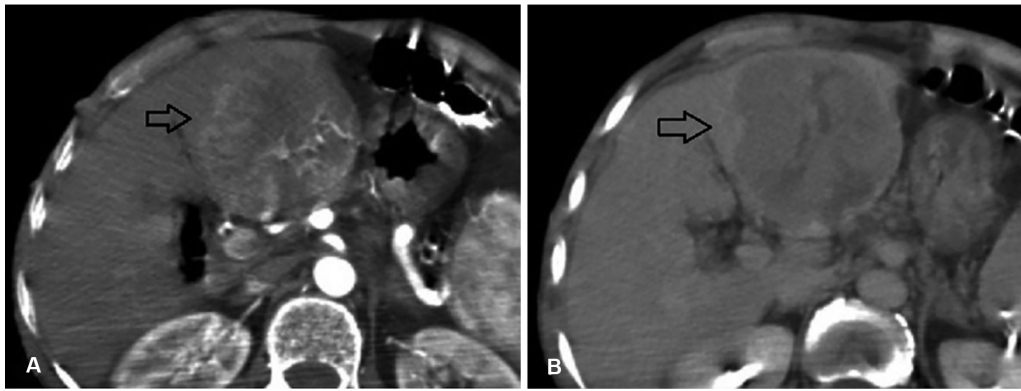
Triphasic computed tomography of the liver demonstrating a left lobe mass (arrow) with arterial enhancement (A), and delayed washout (B) consistent with hepatocellular carcinoma.
